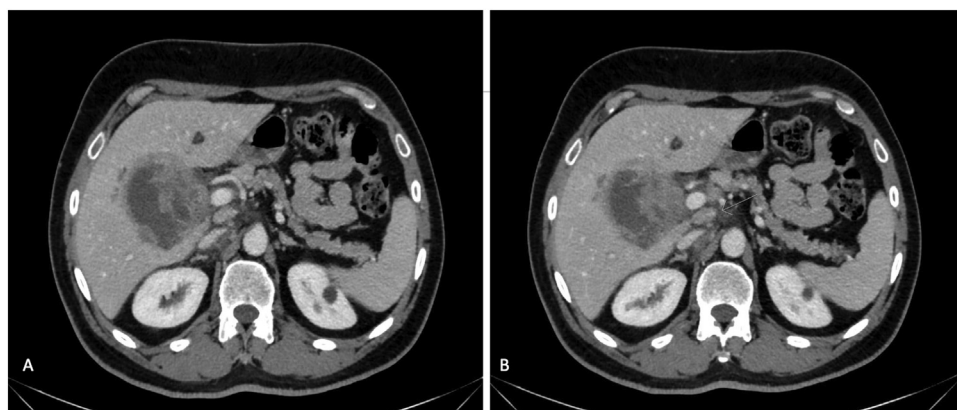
A and B: A: Computed tomography scan of the chest and the abdomen revealing a large gallbladder mass lesion measuring 6×4 cm with solid and cystic components infiltrating the liver. B: Computed tomography scan of the chest and abdomen revealing enlarged portocaval lymph nodes, with the largest node measuring 2.7×1.7 cm. In contrast, the pancreas had a normal appearance and the bile ducts were not dilated.
